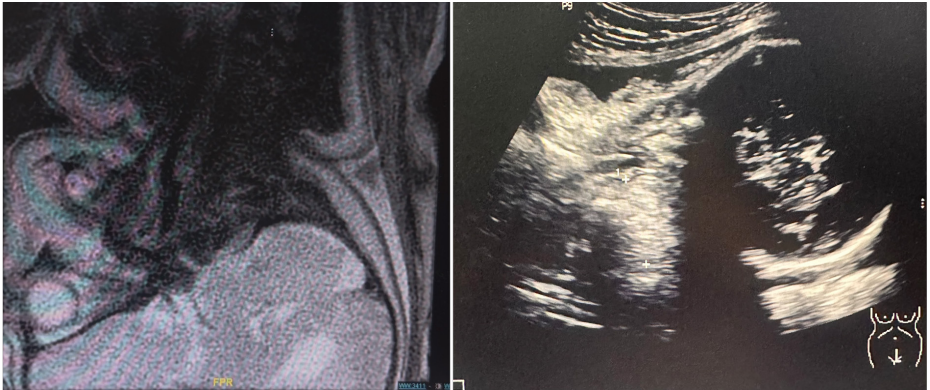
(Left) MRI scan of the foetus showed an irregularly shaped lesion in the anterior neck region. A complementary ultrasound scan of the foetus (Right) showed an irregular echogenic lesion, possibly of thyroid origin. The airway appears to be patent on both imaging studies.
